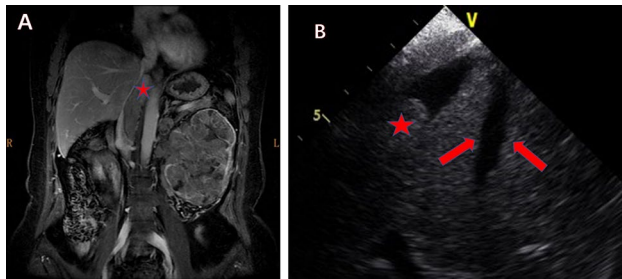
Tumor thrombus above the hepatic vein in an infradiaphragmatic location as shown on preoperative magnetic resonance imaging (Level III) (a); two-dimensional transesophageal echocardiogram long-axis view of the intrahepatic inferior vena cava demonstrating a tumor thrombus (asterisk) caudad to the ostium of the hepatic vein (arrow) (Level II) (b)
